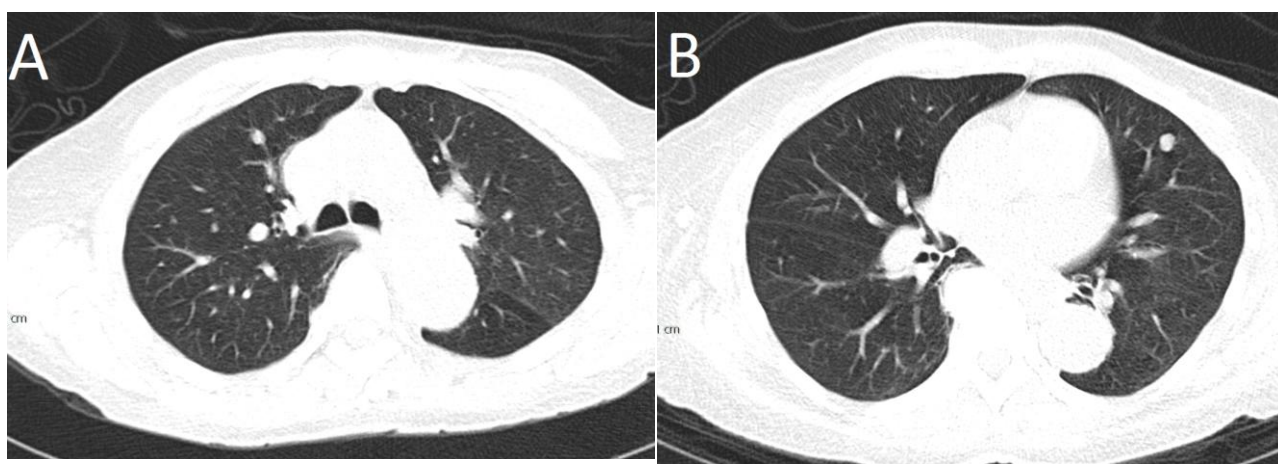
CT chest: Axial sections (lung windows) showing multiple bilateral lung nodules, suspicious for metastases.
